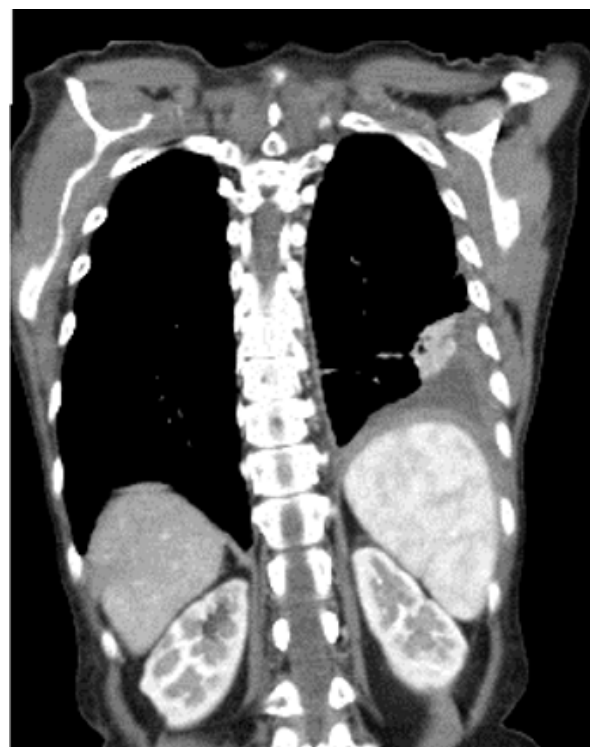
Chest CT scan showing left pleural effusion
